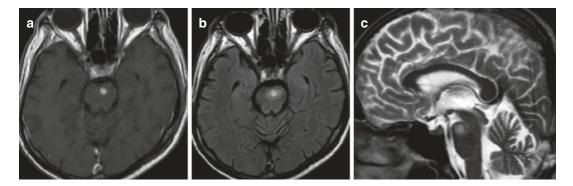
TB granulomas are seen in the mesencephalon on axial contrast-enhanced T1-weighted (a), axial FLAIR (b) and sagittal T2-weighted (c) images
